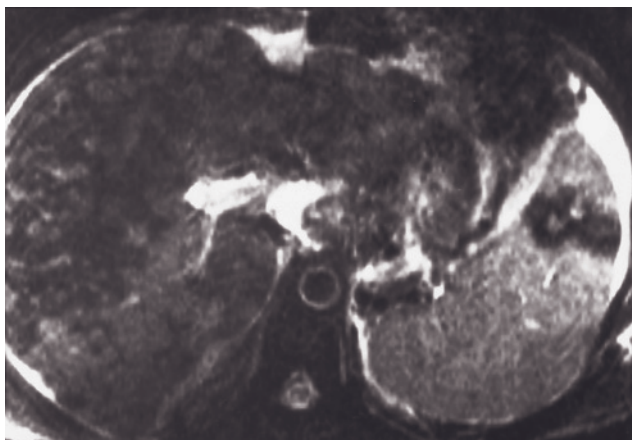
Multiple malignant insulinomas. T1-weighted fat-suppressed spin-echo images (*a, b*). Multiple low-signal intensity insulinomas (arrows, *a, b*) ranging in diameter from 1 to 5 cm are present throughout the pancreas. Intervening pancreatic tissue is noted to be normal in signal intensity (long arrow, *a*). Liver metastases are also present (curved arrow, *a*). Multiple insulinomas are uncommon, occurring in <10% of all cases of B cell tumors.
